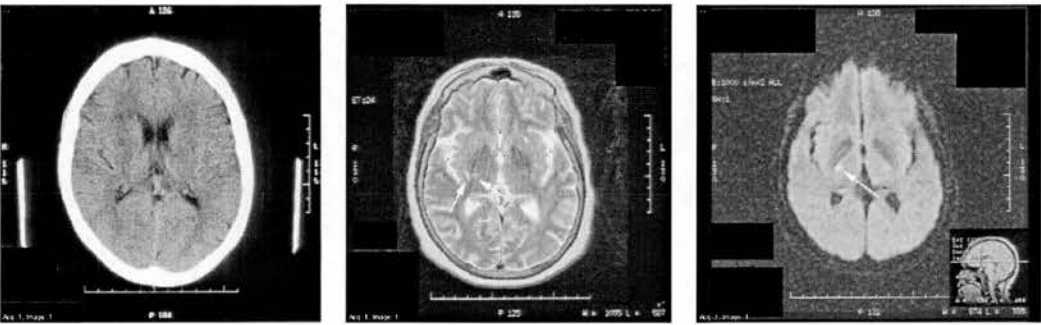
CT (left), conventional MRI (T2-weighted, middle) and DWI (right) scans performed within 24 hours of each other, of a patient with sudden onset left leg weakness and left arm tingling. Note no identifiable area of hypodensity on CT, various areas of increased signal on T2 MR but none distinguishing, and obvious small area of increased signal in the right internal capsule on DWI (arrows).
